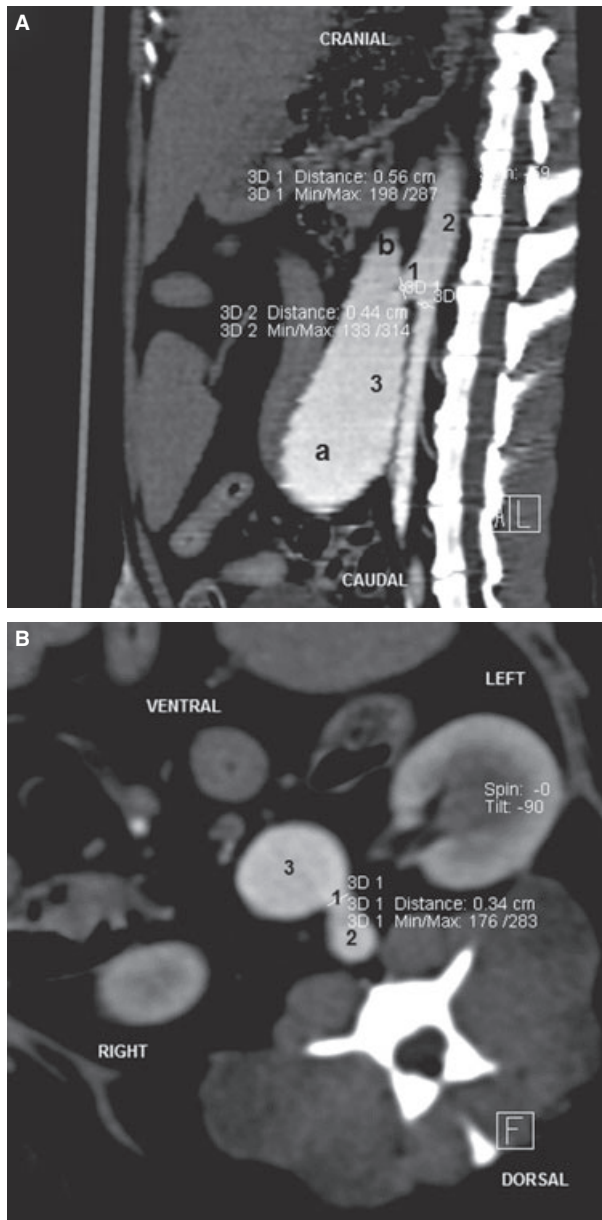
Contrast computed tomography. (A) Parasagittal and (B) transversal images showing the connection (1) between the abdominal aorta (2) and the dilated caudal vena cava (3). (A) The dilatation caudal to the shunt was 2.6-fold greater than (B) the dilatation cranial to the shunt
